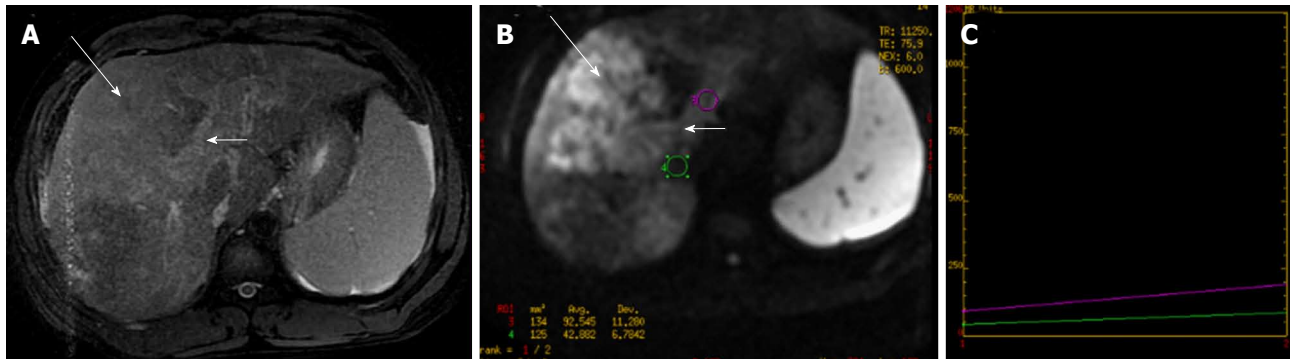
Pre-therapy magnetic resonance imaging in 57-year-old patient with hepatocellular carcinoma. A: DCE MR of liver showed enhancing lesion in segment V, VI, VII and VIII of the liver (long arrow-A) with enhancing portal vein thrombus (short white arrow-A). Diffusion weighted imaging revealed restricted diffusion in the hepatic lesion (long arrow-B) and the portal vein thrombus (short arrow-B) with reduced ADC values (B and C). Biopsy revealed hepatocellular carcinoma. Thus DWI helps in confirming the diagnosis of malignant portal vein thrombosis. ADC: Apparent diffusion coefficient; MR: Magnetic resonance; DWI: Diffusion-weighted imaging.
